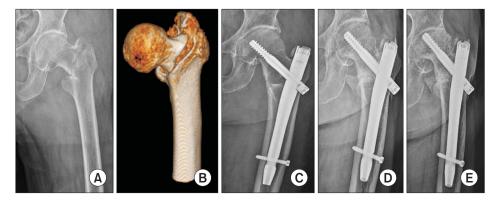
Initial radiograph (A) and 3-dimensional computed tomography (B) of a 91-yearold woman showing a pertrochanteric fracture. Postoperative radiograph (C) and anteroposterior radiograph (D) at 36 months after surgery, showing good reduction status and bone union. (E) Anteroposterior radiograph showing osteonecrosis of the femoral head at 41 months after surgery.
